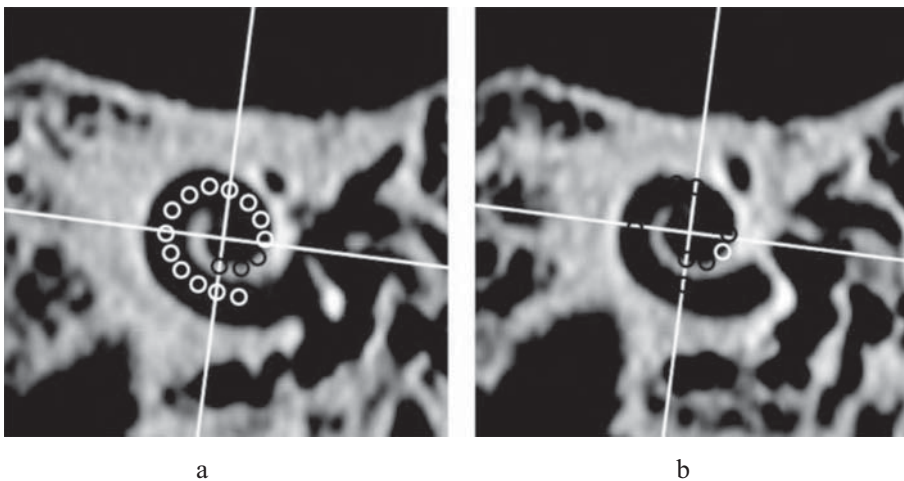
realignment of the CT-based 3D cochlear coordinate system: markers indicating the position of 16 electrode contacts were obtained from postoperative images and inserted into preoperative CT images (white: contacts marked in the current image, black: contacts marked on another image). In (a) all white markers project in the cochlear lumen (grade 1), corresponding to a perfect fit of the coordinatessystem applied on pre-and postoperative images. In (b) the center of the white marker projects outside the cochlear lumen (grade 3).
